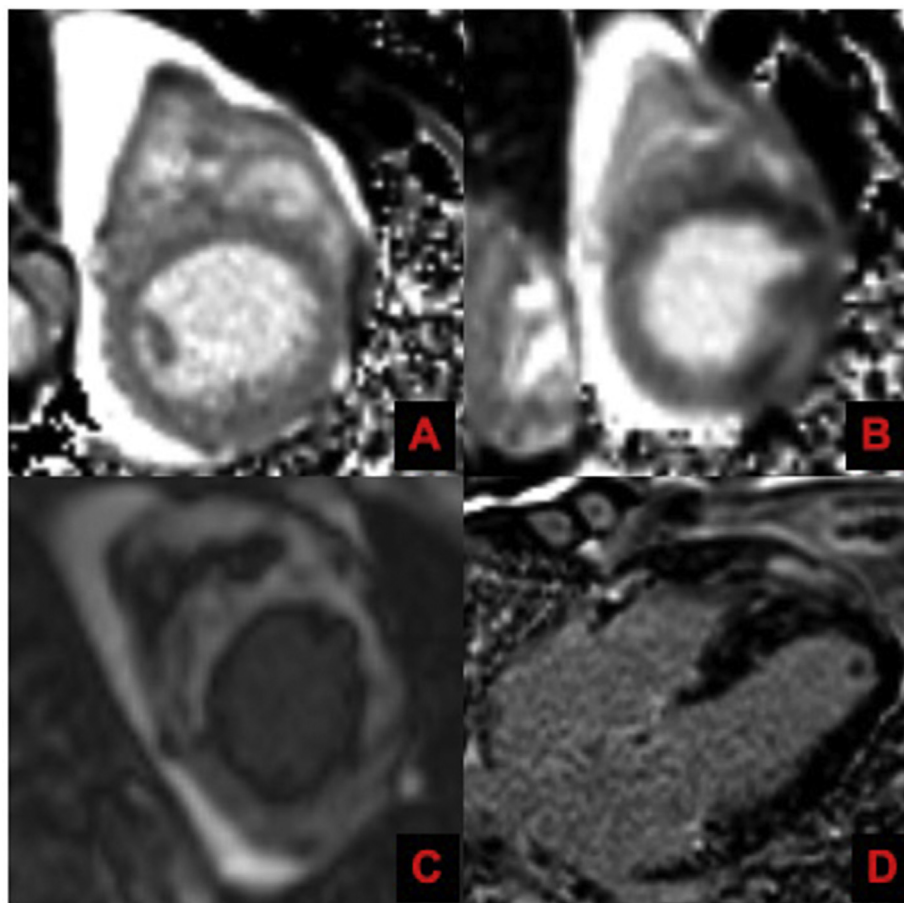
Cardiac magnetic resonance imaging (MRI) of the left ventricle at (A) mid, and (B) apical levels demonstrated patchy non-ischemic infiltrates involving left ventricular apex, right ventricular apex and interventricular septum. (C) Late gadolinium enhancement was seen in the same areas at left ventricular apical level. (D) Pericardial effusion with no tamponade and left ventricular apical thrombus were present.
